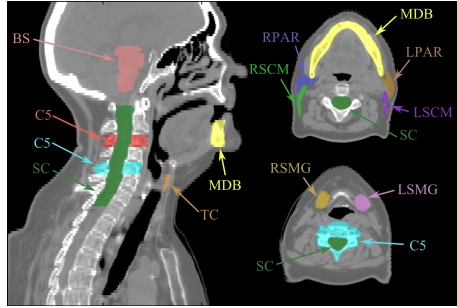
Structure set manually delineated on the CT and MRs of each patient.
